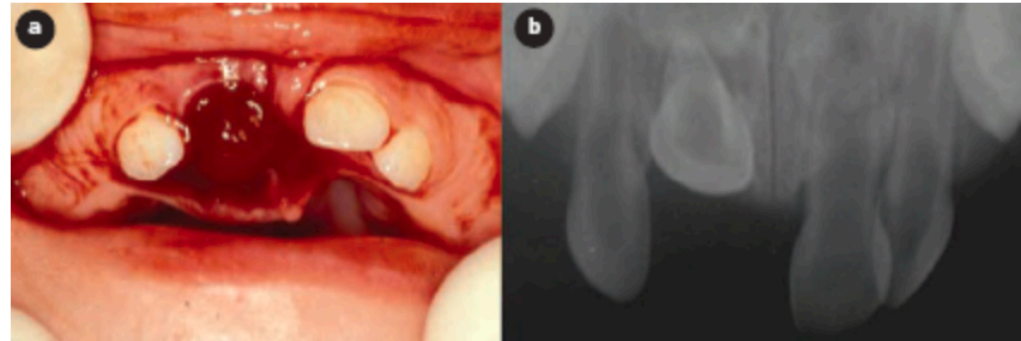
Initial examination: a) clinical view of the traumatized area; b) radiographic aspect of the intruded tooth.
